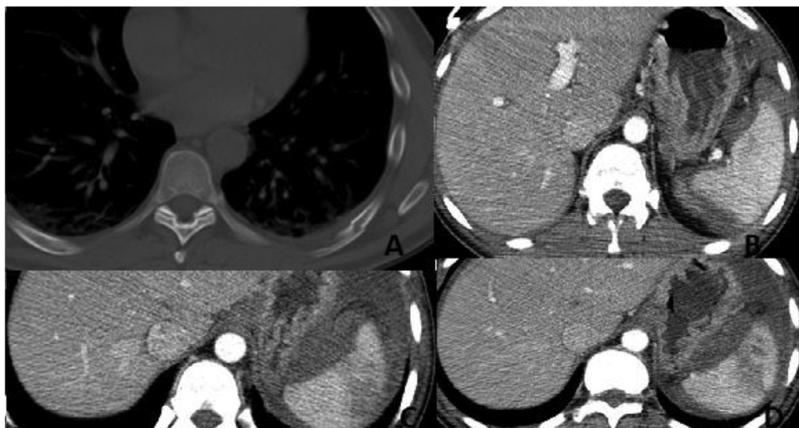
Computed tomography (CT) examination. A 36-year-old woman victim of repeated kicks in the left flank with dislocated ipsilateral rib fracture, splenic parenchyma rupture with hemoperitoneum (A-D).
